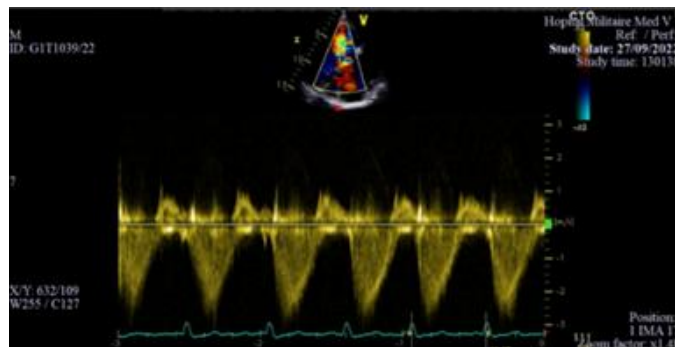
Echocardiographic image in apical four-chamber view showing a laminar tricuspid regurgitation on continuous Doppler.
